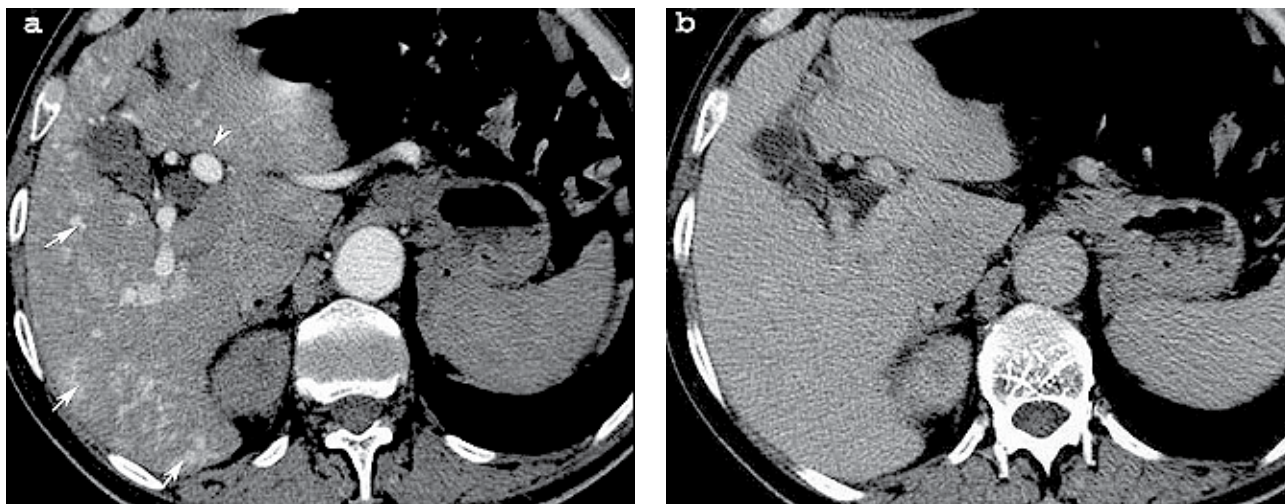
Hereditary hemorrhagic telangiectasia. a - CT arterial phase; b - portal venous phase: tortuous hepatic arteries and arteriovenous and portovenous fistulas.
